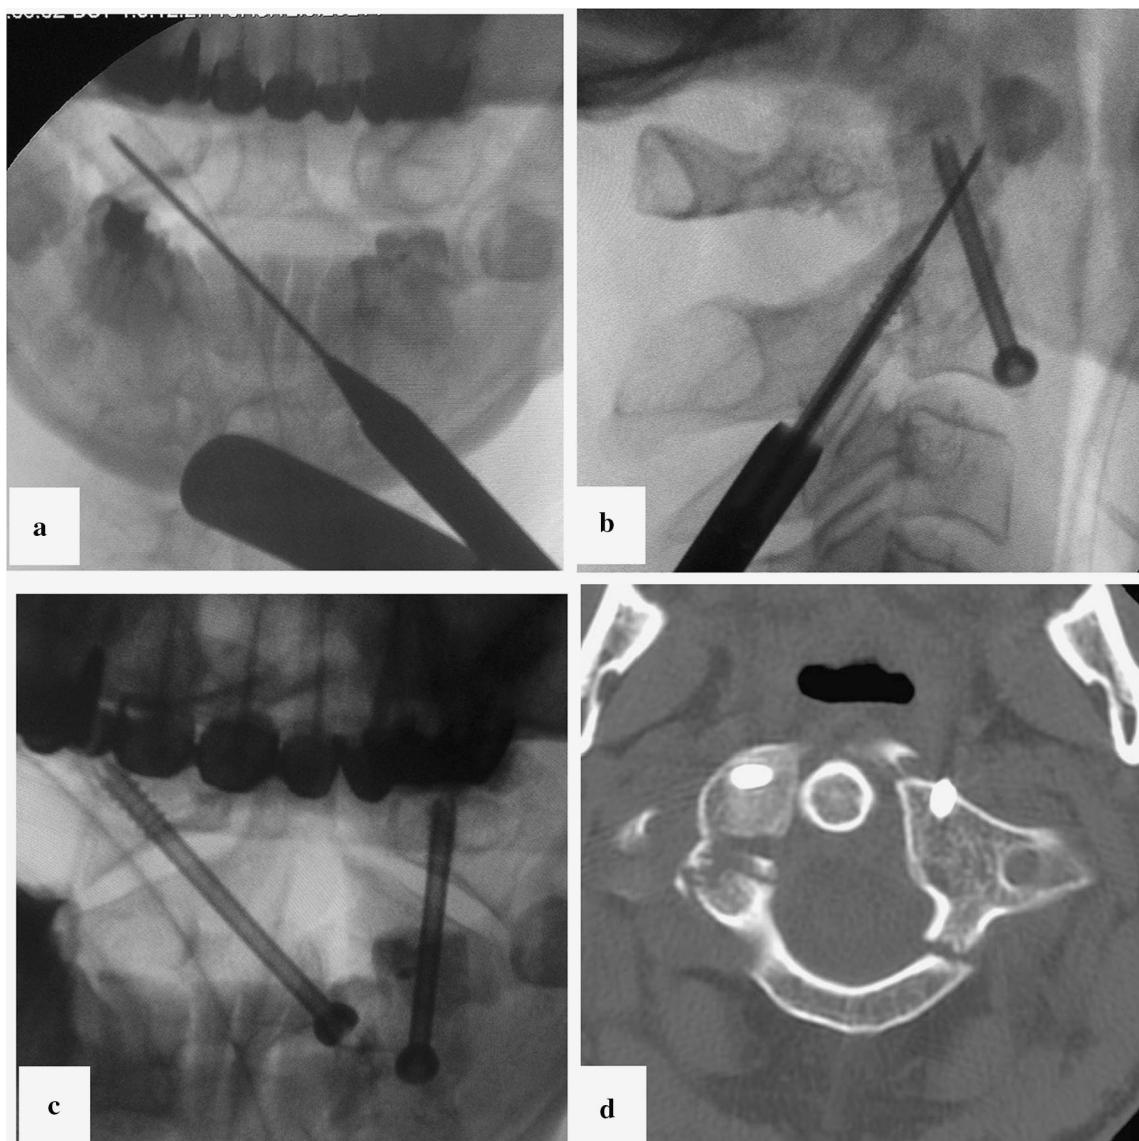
Case 1: X-ray images of the fixation stages and control CT scan. a K-wire insertion into the right lateral mass using a contralateral trajectory. b Left-sided unilateral posterior transarticular fixation. c Control X-ray in the transoral plane. d CT scan control
